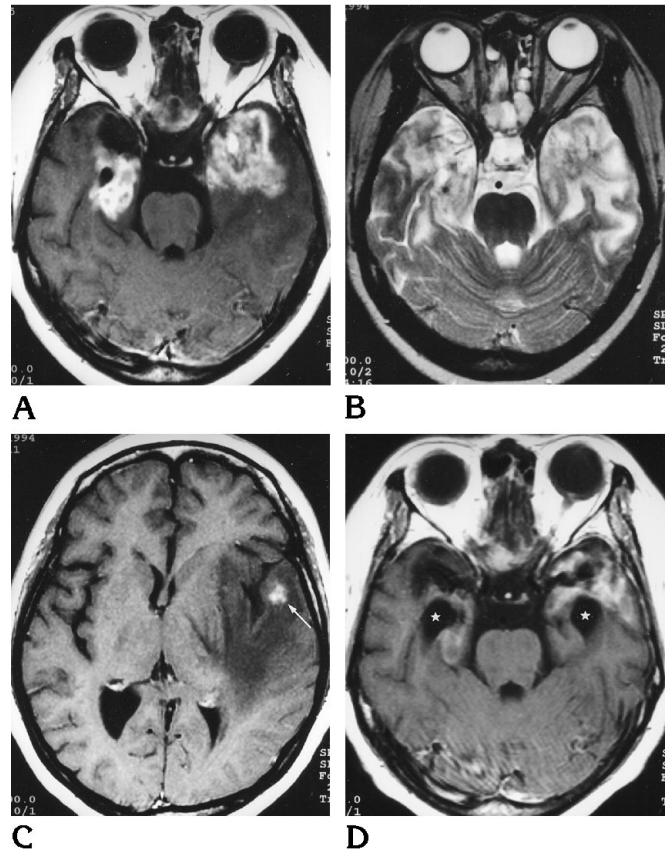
A, Axial contrast-enhanced MR image (600/15/2 [repetition time/echo time/excitations]) shows enhancing lesions in both temporal lobes.
